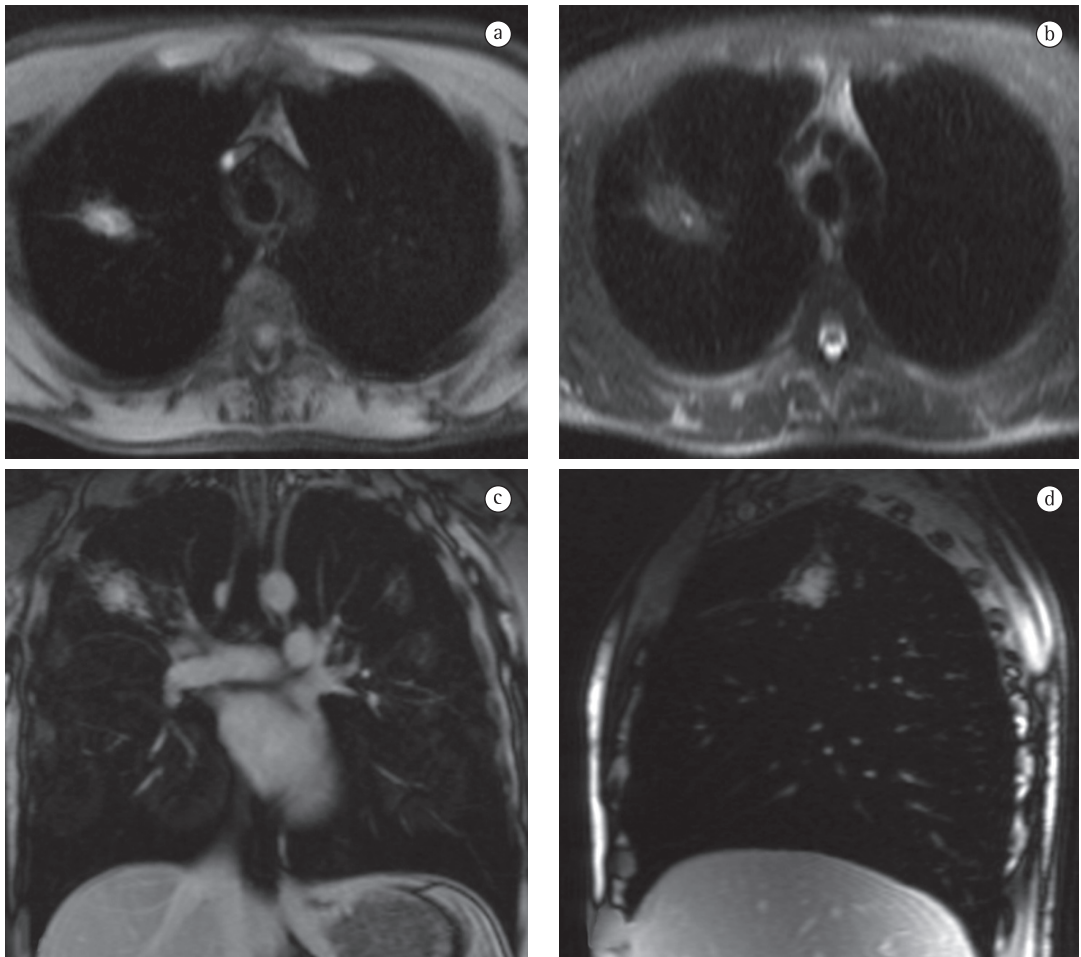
Magnetic resonance images showing pulmonary aspergilloma. Axial T1-weighted image (a), axial T2-weighted image (b), coronal contrast-enhanced T1-weighted image (c), and sagittal contrast-enhanced T1-weighted image (d). Note irregular nodular lesion at the right lung apex of an immunocompromised patient with laboratory test results confirming infection with *Aspergillus* sp. The nodule presents heterogeneous signal intensity—including an area of hyperintensity on T1-weighted images probably due to hemorrhage—and nearly homogeneous contrast enhancement.
